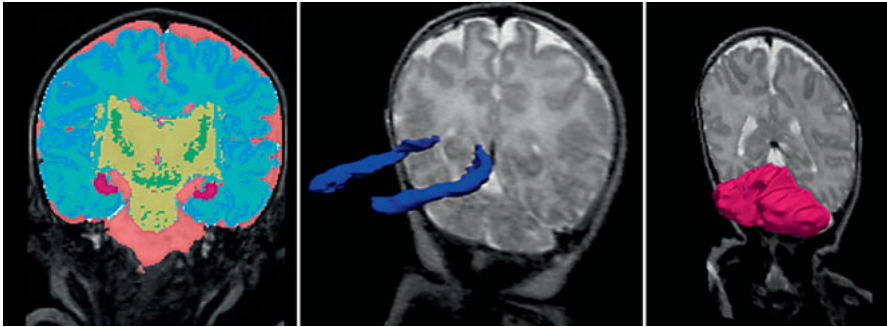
3-D MRI in brain development. Examples of MRI segmentation classifying the brain into different tissue classes such as cortex, unmyelinated and myelinated white matter, basal ganglia but also specific brain structures such as the hippocampi and the cerebellum, which then allows absolute quantification of these brain structures.
